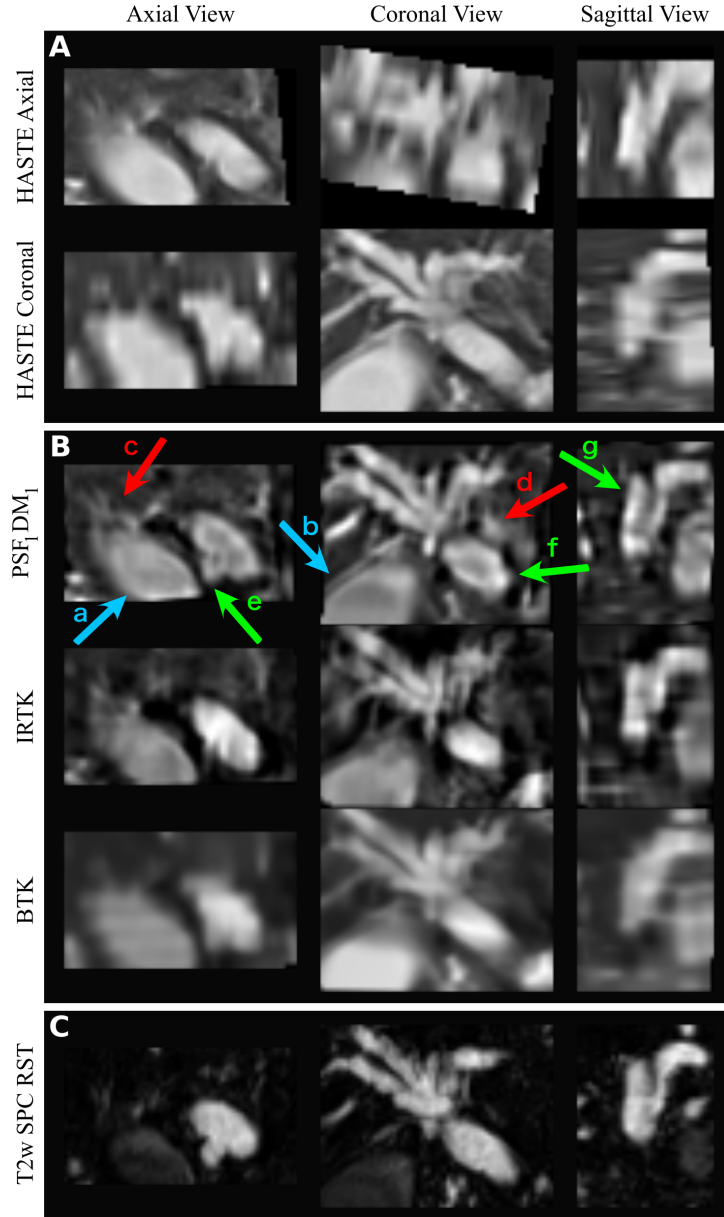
Qualitative comparison between linearly resampled original HASTE data (A) and reconstructions obtained by BTK, IRTK and our proposed approach (B). Reconstructions are based on one axial and one coronal HASTE stack only. Several arrows on our reconstruction show examples of successfully preserved raw data information (blue *a* and *b*), introduction of artifacts (red *c* and *d*) and resolution improvement (green *e*, *f* and *g*) in direct comparison with the other reconstruction approaches. Artifacts are explained by similar intensities in the original data (*c*) in addition to the complex deformation occurred between axial and coronal stack acquisition (*d*). Resolution improvement was achieved by the combined usage of SR and the incorporated heavily T2-weighted volume information (C) as reference during motion correction.
